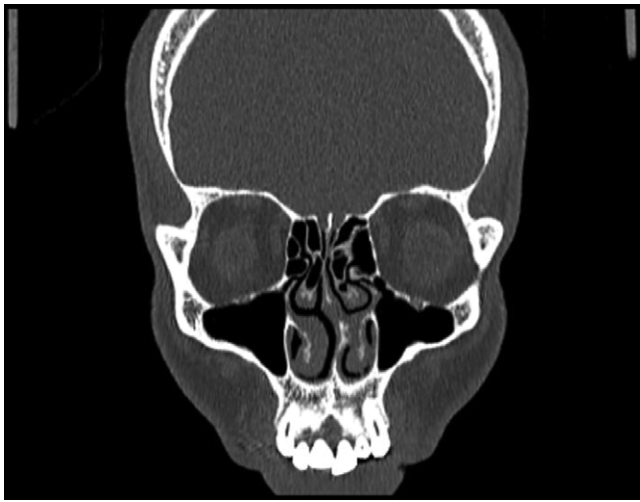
Coronal paranasal computed tomography scan of a patient with nasal septal deviation.
